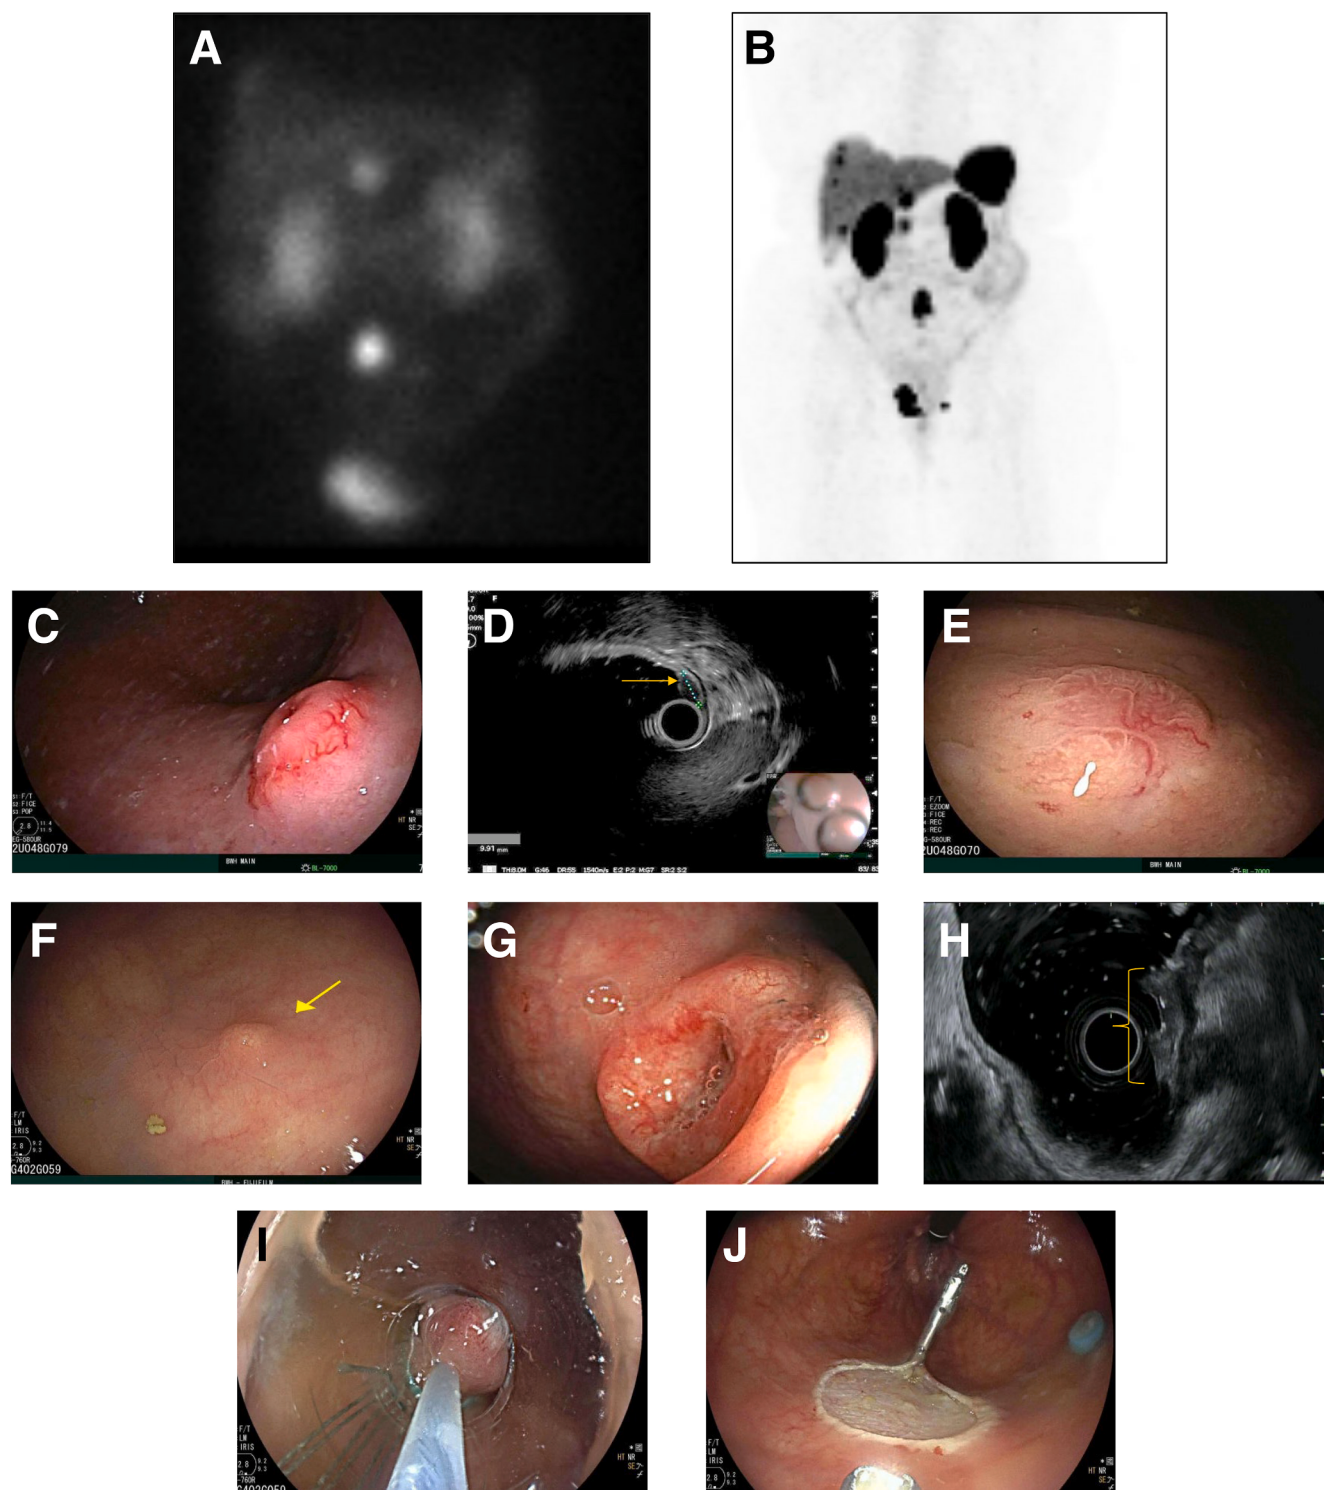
Functional and endoscopic imaging for NETs. (A) ^{111}In -pentetreotide SPECT scan and (B) ^{68}Ga -DOTA-TATE PET scan for the same patient taken 4 months apart. PET imaging provides significantly better image resolution and localization, and also shows many additional lesions not visualized on SPECT imaging. (C) Endoscopic image of type 1 gastric NET (grade 1, Ki-67 <3%) in a background of atrophic autoimmune gastritis. (D) EUS image of type 1 gastric NET. (E) Endoscopic image of type 3 gastric NET (grade 2). (F) Endoscopic image of rectal NET (grade 1, Ki-67 <3%). (G) Endoscopic image of rectal NET (grade 3, Ki-67 60.2%). (H) EUS image of rectal NET (between bracket). (I) Band ligator endoscopic mucosal resection. (J) Resection site after endoscopic mucosal resection. SPECT = single photon emission computed tomography.
